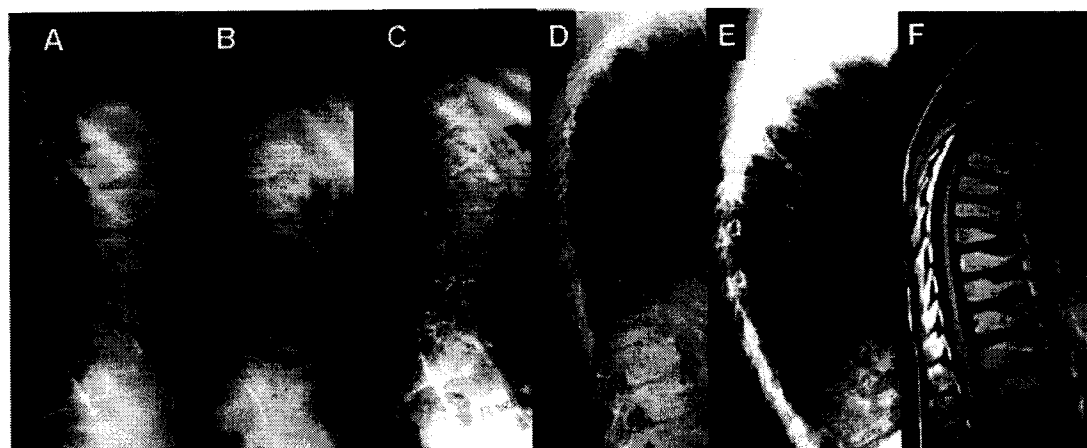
Bone changes in lateral spine X-rays in several PPRD patients at different ages. Involvement of the vertebral bodies may be mild at early stages (A = 6 years) and becomes evident with age, with progressive platyspondyly and anterior beaking of the vertebral bodies (B = 12 years; C = 13 years; D = 16 years; E = 21 years). Dorsal kyphosis and osteopenia are observed in adolescence (D = 16 years; E = 21 years). F = MRI section of lateral thoracic spine at age 12, showing platyspondyly, reduced intervertebral space and anterior beaking of the vertebral bodies.
